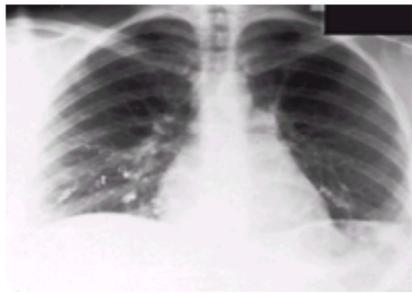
Chest roentgenogram of the patient shown in [Fig. 8](#) after multiple steel-coil embolizations. This patient has required several embolizations for recurrent arteriovenous malformations.
